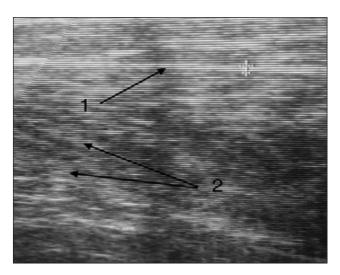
A 14-year-ol patient K., diagnosis: cerebral palsy with reflex tonic muscle tension. Sonography of the calf muscle: 1 - fascia, diameter - 0.5; 2 - muscle fibers of the oblique-longitudinal direction
